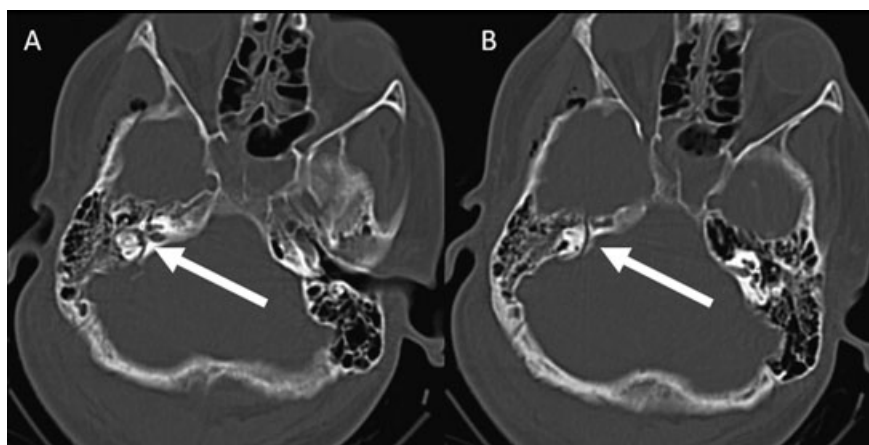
Axial CT images (A, B) show a transverse petrous bone fracture, crossing the cochlea and osseous canal of the facial nerve, extending into the region of the geniculate body. Small air bubbles are seen within the temporal and infratemporal fossa. The imaging findings match the clinical findings which include ipsilateral deafness and facial nerve palsy.
